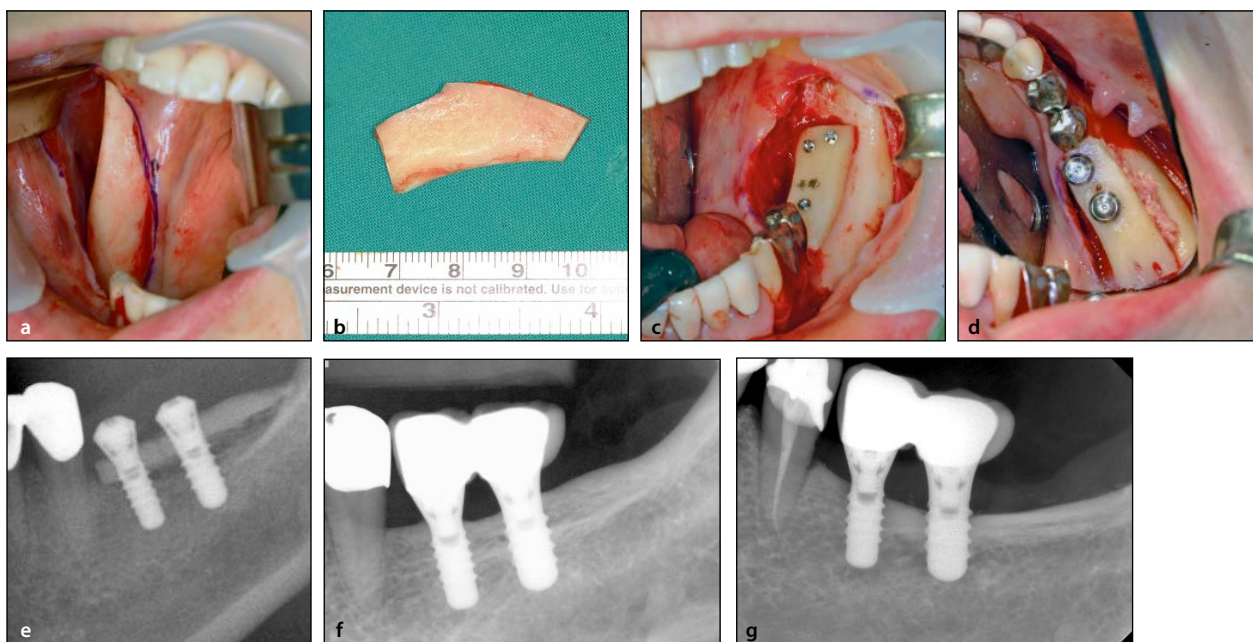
Onlay bone graft harvested from the contralateral mandibular ramus. (a) Donor site (right mandibular ramus) before block harvesting. (b) Harvested bone block from the mandibular ramus. (c) Vertical reconstruction of the alveolar ridge with bone blocks. Site of implant insertion was marked with pencil. (d) After placement of implant, fixing screws were removed when implant was placed simultaneously. Clinical view of grafted bone and placed implant. (e) Panoramic radiograph taken immediately after surgery. (f) Periapical view after 2 years. (g) Periapical view at 11 years postoperatively.
